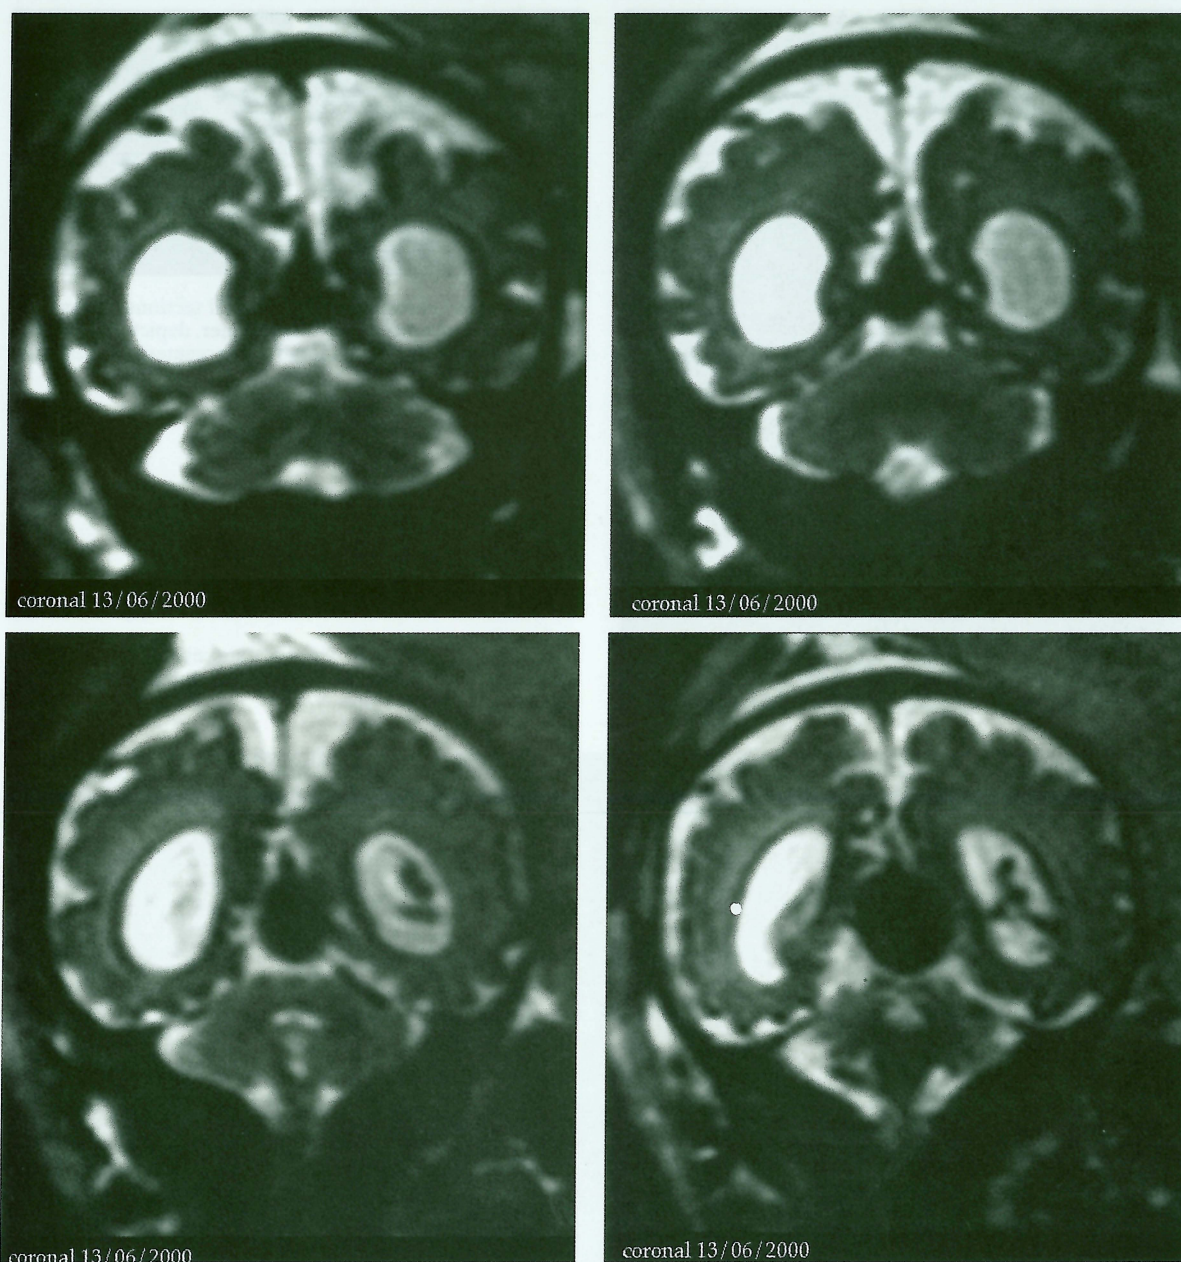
The first MRI (13-6-2000) displayed cerebral atrophy, dilatation of the Galen vein and the lateral ventricles, and white matter hypersignal in the periventricular area mostly on the right.
